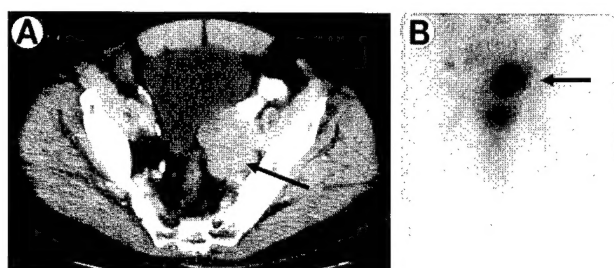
CT (A) showing soft tissue mass measuring 4 x 6 cm in left pelvis. Anterior view of J591 scan (B) showing accumulation in left pelvic mass.
